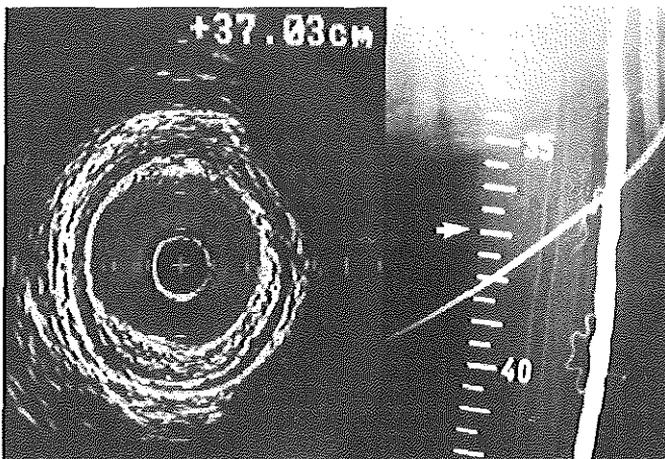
Intravascular ultrasound cross-section and angiogram obtained clinically. The position of the ultrasound catheter at 37.03 cm is indicated on-line by the displacement sensing device. The accuracy of this information was verified by identification of sidebranches seen with angiography and ultrasound. Calibration 1 mm.
